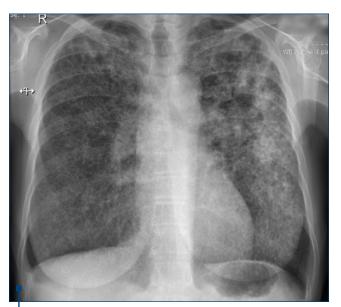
Chest X-ray, AP incidence: disseminated micronodular opacities
